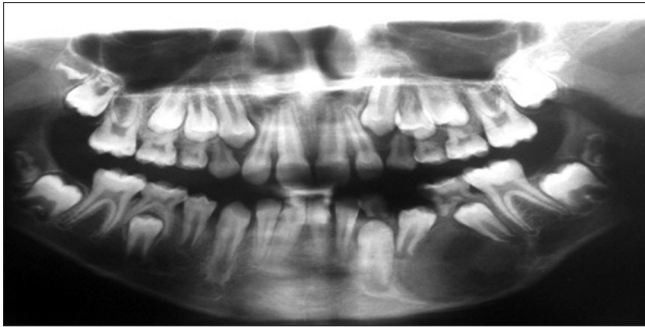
Panoramic radiography feature after 4 months: Healing process observed
